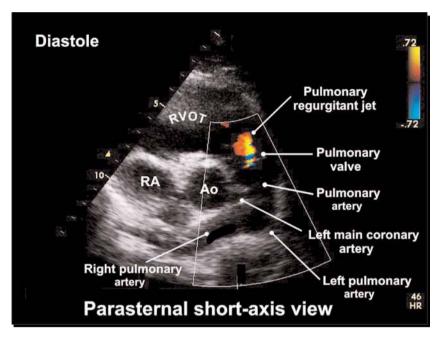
Parasternal short-axis (PSAX): aortic valve level. (A,B, see companion DVD.)
